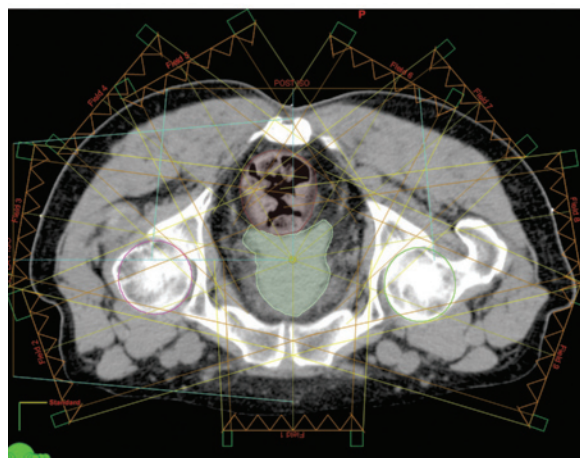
CT scan with superimposed color coding shows an RT Structure Set, which includes tumor volume (outlined in red), OARs (femoral heads [green and pink], rectum [purple], bladder [blue]), and body contour.
